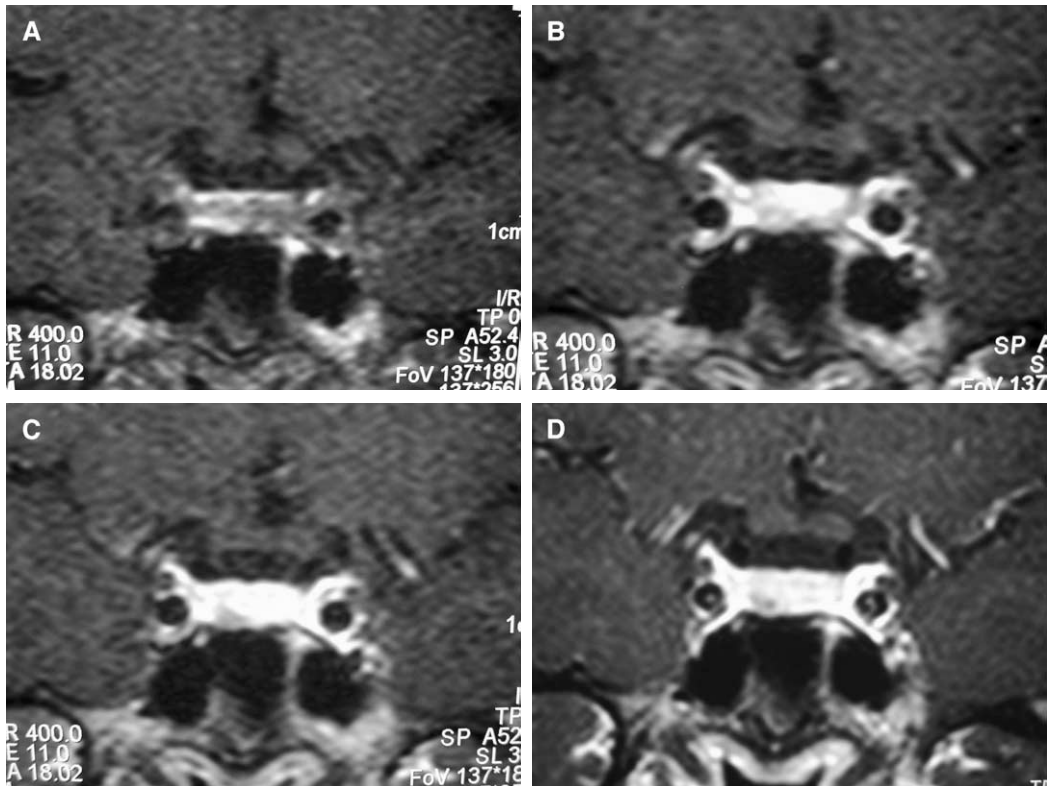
Dynamic sellar MRI study for pituitary microadenoma. (A) Coronal dynamic postcontrast image obtained 20 seconds after injection of contrast material demonstrates a focal area of contrast enhancement over the right inferior aspect of the pituitary gland. (B) Coronal dynamic postcontrast image obtained 40 seconds after injection demonstrates a focal area of decreased contrast enhancement over the right inferior aspect of the pituitary gland, which begins to show intense enhancement. (C) Coronal dynamic postcontrast image obtained 80 seconds after injection demonstrates a focal area of decreased contrast enhancement over the right inferior aspect of the enhancing pituitary gland. (D) Coronal postcontrast T1-weighted image demonstrates a focal area of decreased contrast enhancement over the right inferior aspect of the pituitary, which is consistent with a microadenoma.
